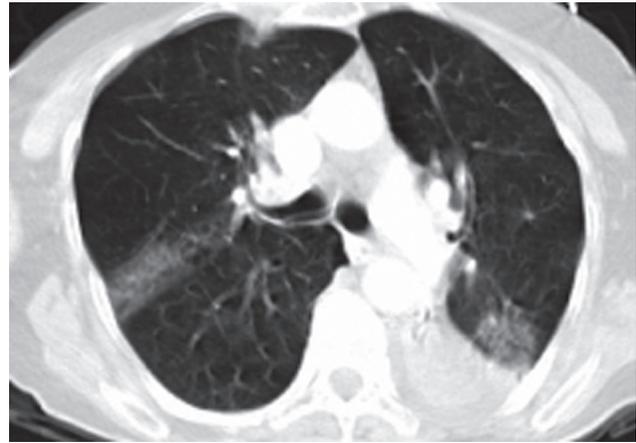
chest CT after orotracheal intubation confirms collapse of the left lower lobe, and shows slight pleural effusion; and bilateral infiltrative changes
